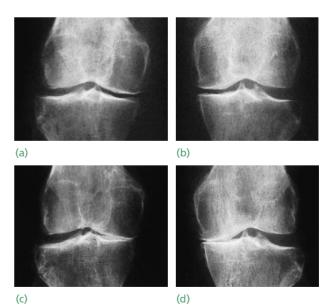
X-rays Anteroposterior views should always be taken with the patient standing. (a,b) X-rays with the patient lying down show only slight narrowing of the medial joint space on each side; but with weight-bearing (c,d) it is clear that these changes are much more marked. *Tibiofemoral alignment* can be measured on fulllength standing views. Normal indices have also been established for patellar height and patellofemoral congruence. These features are discussed in the relevant sections of the chapter. If available, previous X-ray imaging should always be used for comparison to determine progression of changes (typically osteoarthritic) in the knee.
